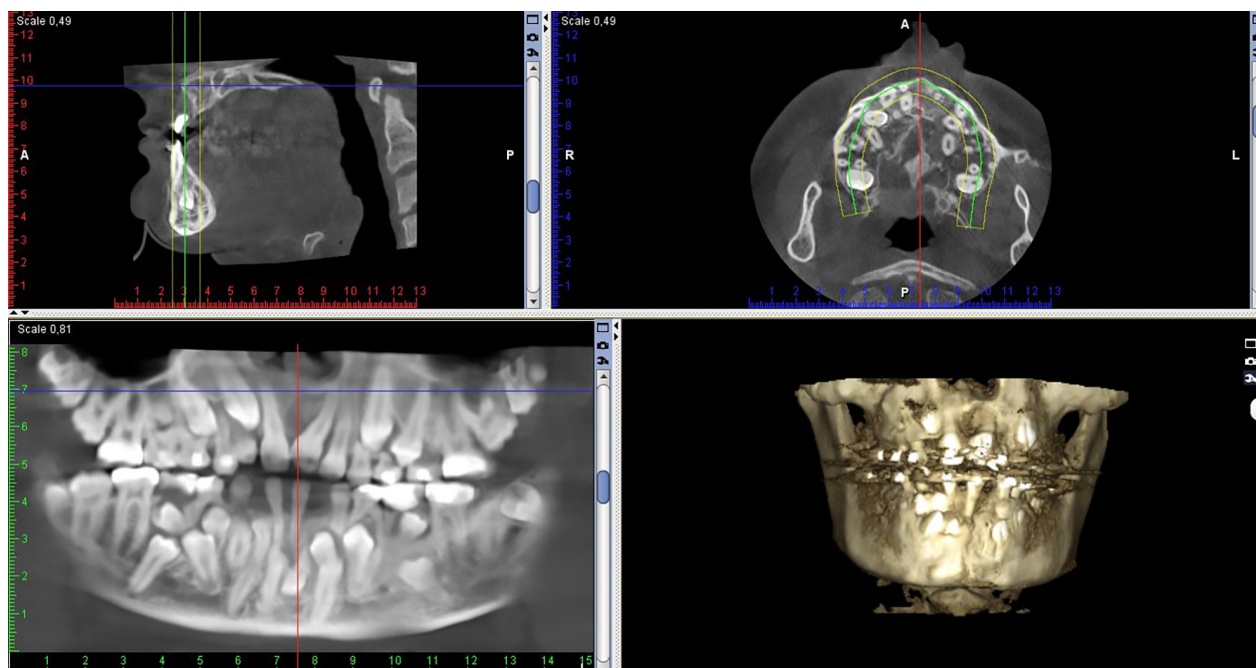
CBCT on patient P.K. in 2017.
